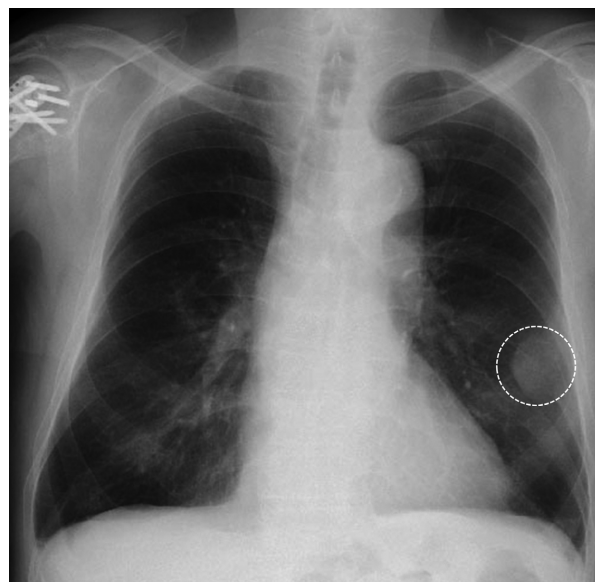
Chest X-ray showing a mass shadow on the left (circled).
